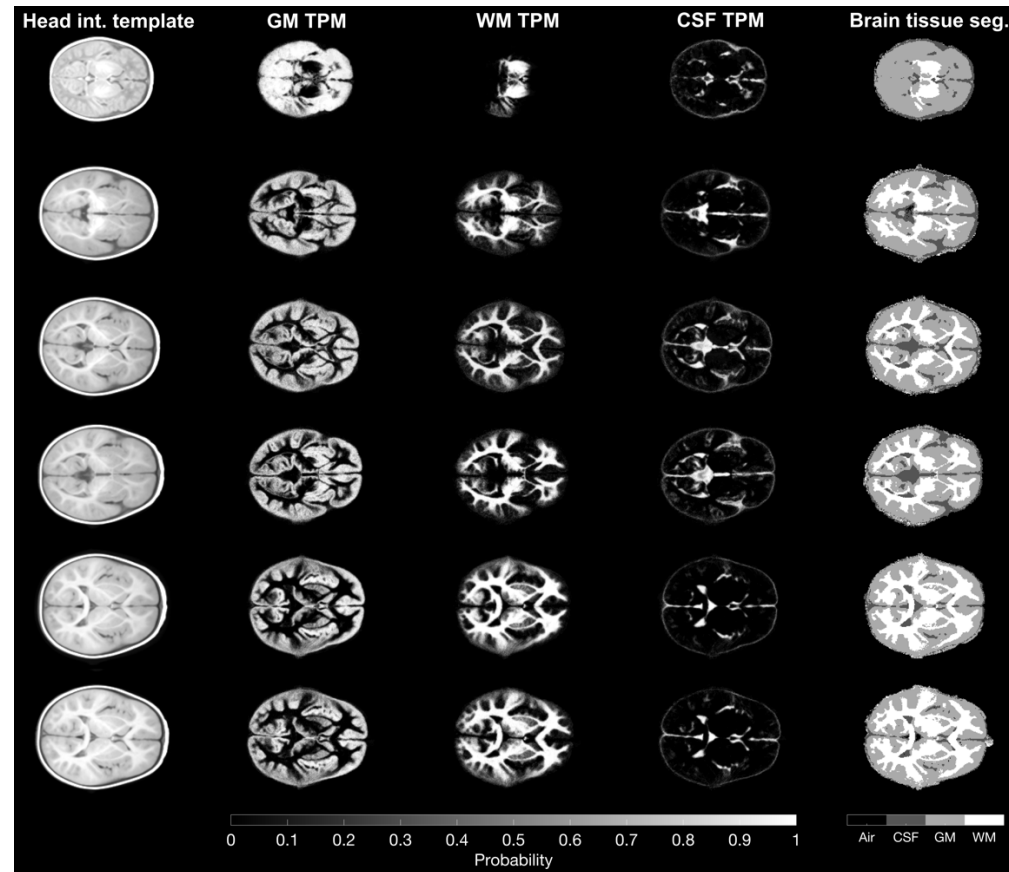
T_1 -weighted averaged MRI data from data published by Sanchez et al. (2012). Left column to right: head intensity (int.) template, grey matter tissue probability map (GM TPM), white matter tissue probability map (WM TPM), CSF tissue probability map (CSF TPM), and brain tissue segmentations (seg.). Top row to bottom: data at 1-, 6-, 9-, 12-, 18-, and 24-months. Data for the figure are detailed in Sanchez et al. (2012) and Richards et al. (2016) and are available from the [Neurodevelopmental MRI database](#), licensed under [CC BY-NC-ND 3.0](#).
